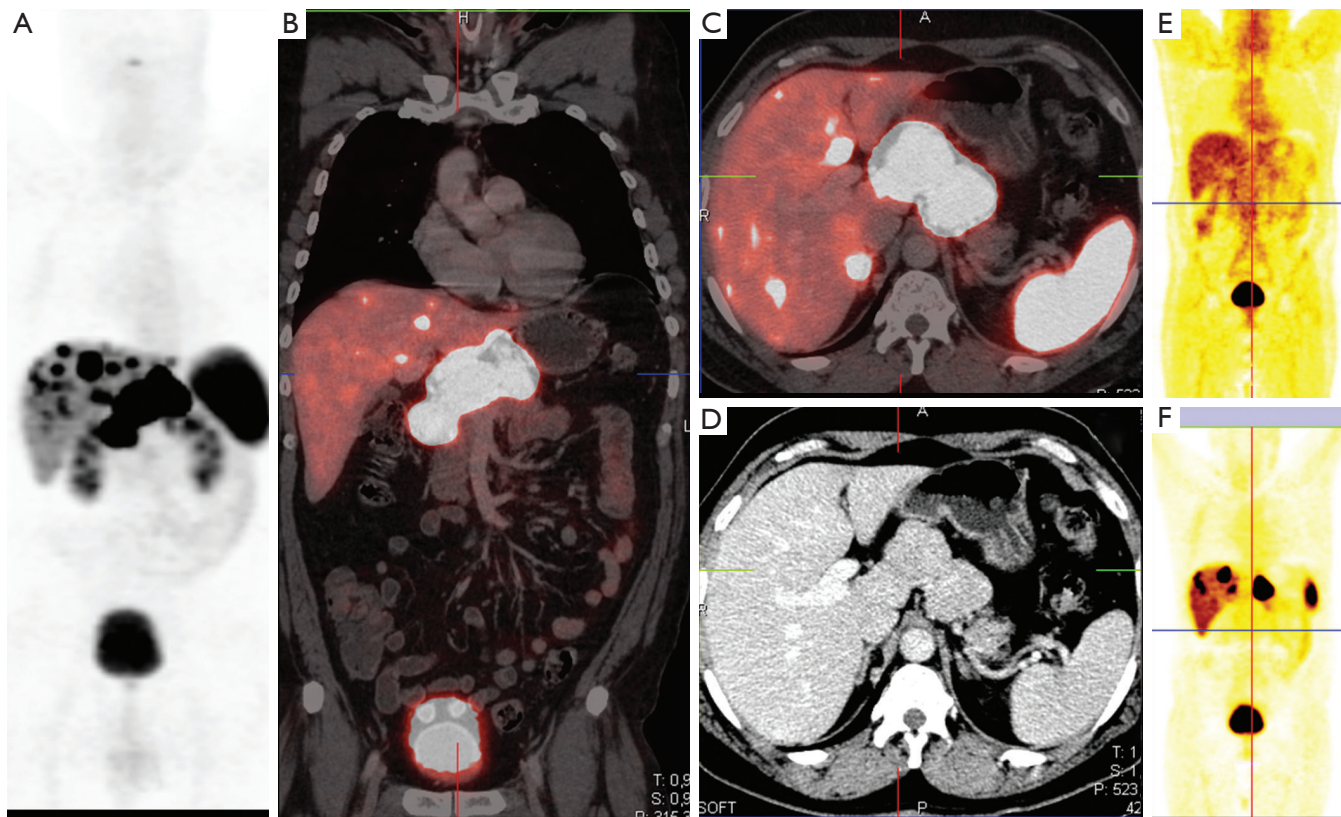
A 60-year-old patient with a well-differentiated, non-functional neuroendocrine neoplasm (NEN) of the duodenum (diameter 4.2 cm × 3.8 cm) and extensive local lymph node metastases in the peripancreatic, portal and lesser omental regions as well as extensive bilobar liver metastases. At initial presentation, endoscopic ultrasound (EUS) guided biopsy of the lymph node metastases was performed, and no liver metastases were detected on EUS. Also, transabdominal ultrasound and multiphase contrast-enhanced CT (CECT) did not show evidence of hepatic involvement. However, somatostatin receptor (SSTR) PET/CT using Ga-68 DOTANOC [(A) maximum intensity projection, MIP image; (B) fused coronal PET and CT; (C) fused transverse PET/CT; (D) shows a slice of the corresponding CT which was negative] showed multiple, intense SSTR positive bilobar liver metastases (maximum standardised uptake value, SUV of 118) and very intense receptor expression in the primary tumor (SUV 151) in the duodenal ‘C’, as well as lymph node metastases in the lesser omentum and peripancreatic region (SUV 137). The FDG PET (E. a coronal slice) was negative, i.e., there was a complete mismatch between the strongly SSTR positive hepatic (shown here in F is a coronal slice of the Ga-68 SSTR PET) and lymph node metastases, and normal FDG metabolism (which is a more favourable prognostic indicator).
